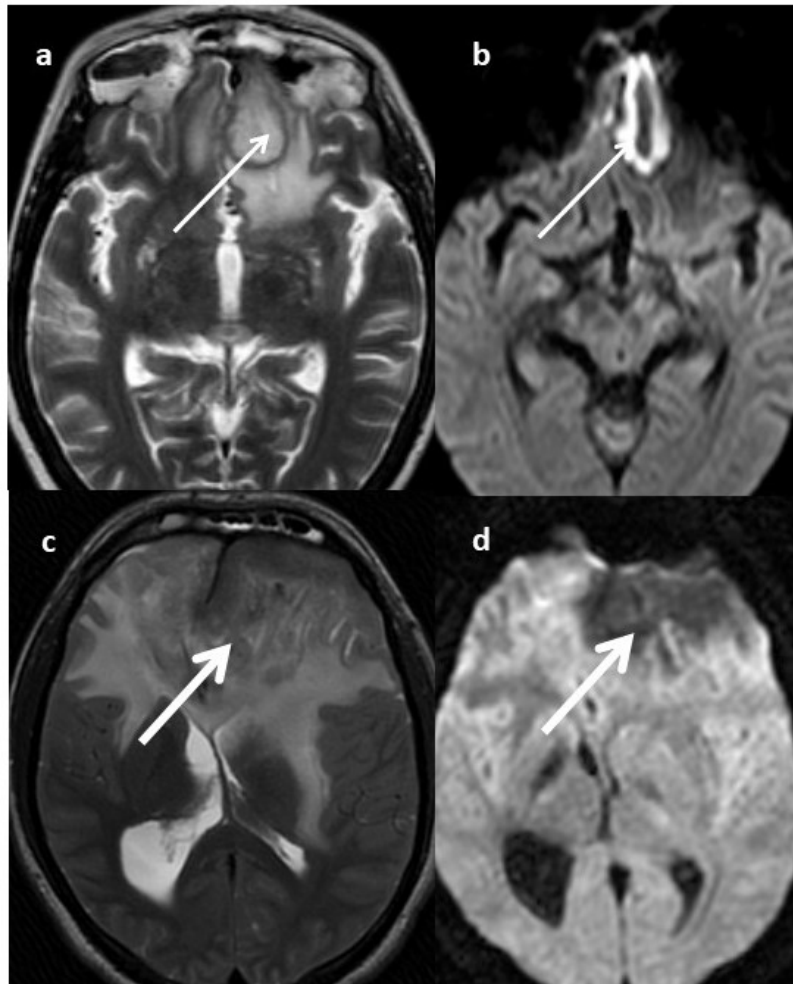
Axial MRI (a) T2 weighted (b) DWI show a large lesion in the left gyrus rectus with peripheral restriction (thin arrows). Axial MRI (c) T2 weighted (d) DWI in another patient shows a large peripherally enhancing abscess in the left frontal lobe with no diffusion restriction (thick arrows).
